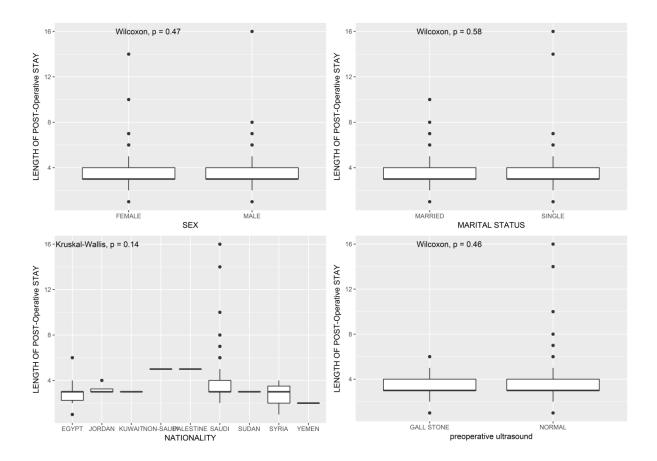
box plots showing the median and IQR of the duration of post-operative stay between different sex, nationality, marital status and preoperative ultrasound.
